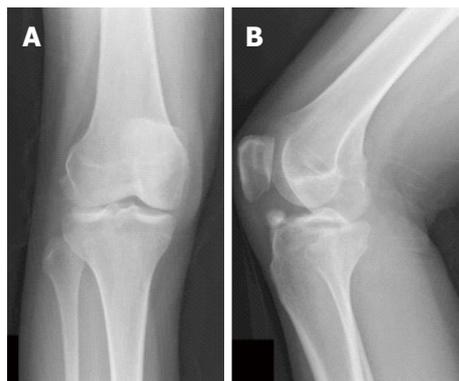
Initial radiographs of the right knee in the anteroposterior (A) and lateral (B) views.
